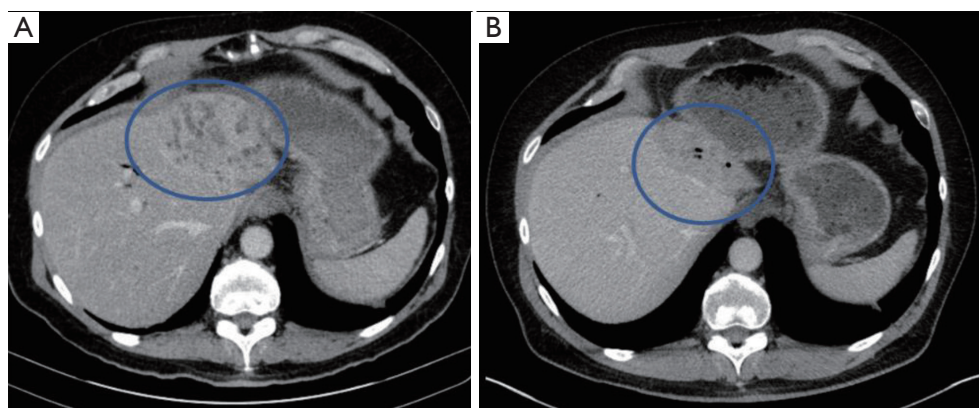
Patient's liver metastatic lesions were normalized after treatment with the combination of ipilimumab and nivolumab. (A) Baseline CT scan image taken in September 2021 prior to initiation of ipilimumab and nivolumab. (B) CT scan image taken in April 2022, 6 months after initiation of treatment. Blue circles in (A,B) indicate the liver metastatic lesions before and after treatment, respectively. After 4 cycles of therapy, the patient remains on nivolumab alone as a monthly maintenance. CT, computed tomography.
